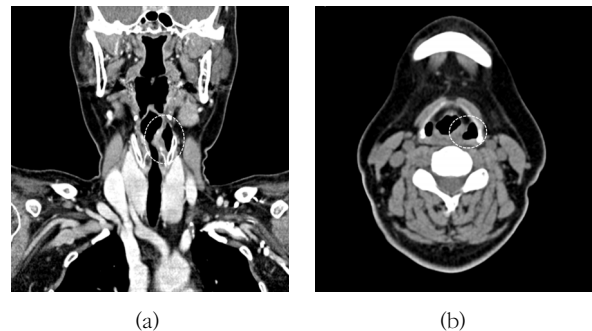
Axial image (a) and coronal image (b) of computed tomography in the neck showed the dilatation of the left piriform sinus with air and medial deviation of the aryepiglottic fold with thickening suggesting recurrent laryngeal nerve palsy (circular dotted point).
